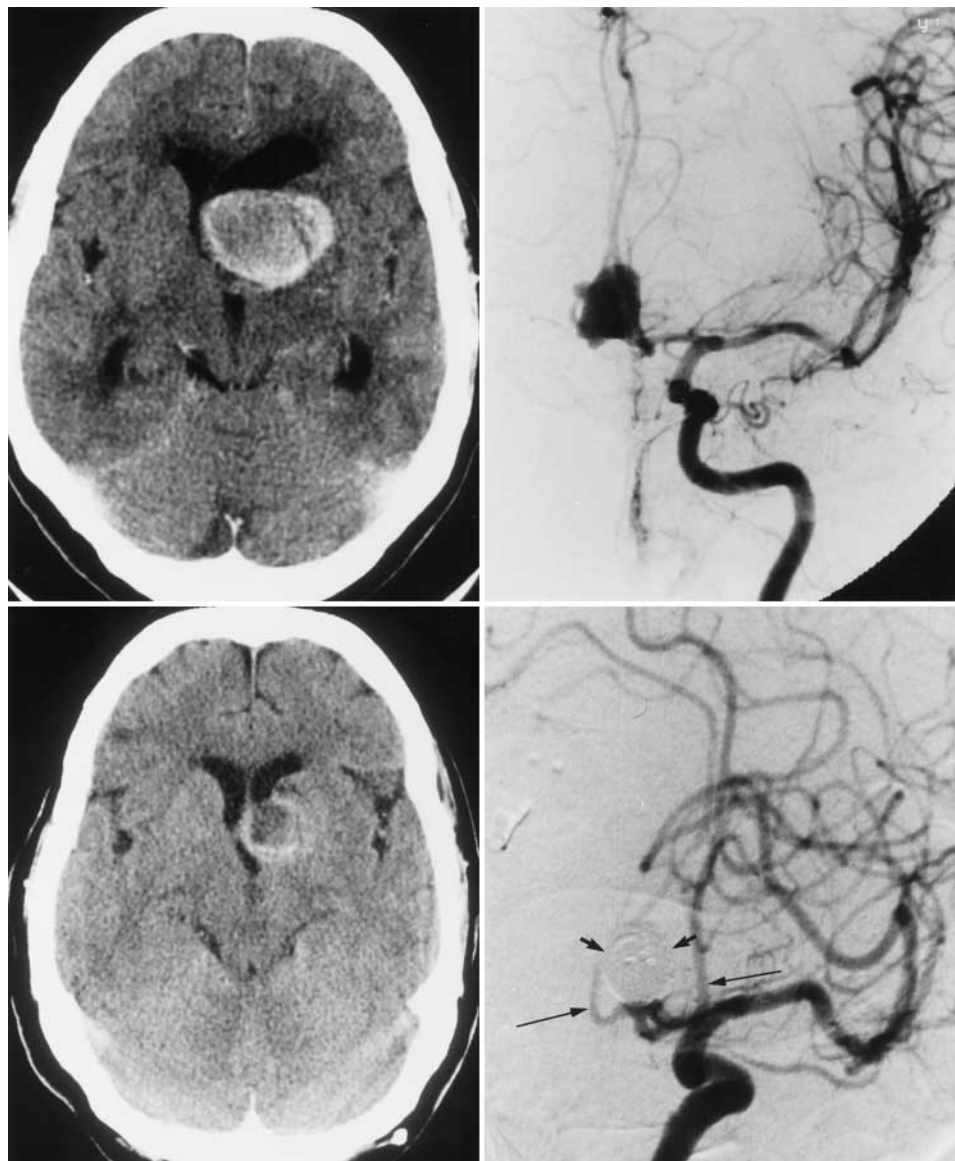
Case 16. *Upper Left:* Contrast-enhanced CT scan revealing a large mass in the left caudate region with involvement of the left lateral ventricle and displacement of the septum pellucidum to the right side. *Upper Right:* Left ICA angiogram (anterior projection). *Lower Left:* Contrast-enhanced CT scan obtained 3.5 years after treatment. Note the marked reduction in the size of the mass. *Lower Right:* Left ICA angiogram (oblique projection) obtained 3.5 years after treatment. The wide-necked aneurysm remains completely occluded by GDCs (*short-tailed arrows*), and both A₂ segments fill well (*long-tailed arrows*).
